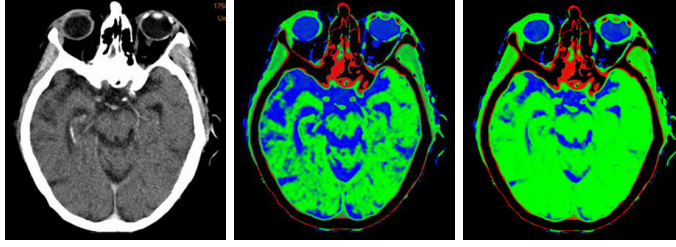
Comparison between FCM and PDI. a) Original CT image. b) FCM results. c) PDI results. In the RGB labels, red is for low intensity bone, green for brain matter and blue for cerebrospinal fluid (CSF). CSF cluster has a large diameter (high variance) causing FCM to assign more pixels to this cluster and misclassify regions of brain matter as CSF. As a result, the brain matter appears very fragmented. PDI corrects this by decreasing the strength of CSF cluster.
